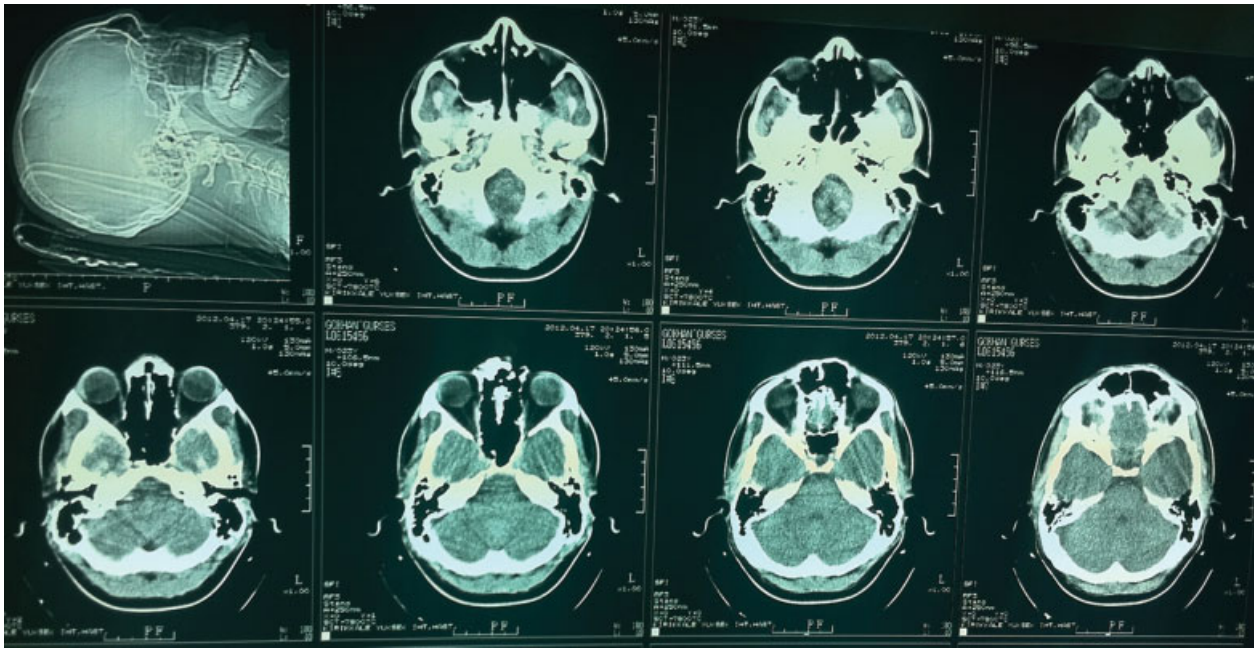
The head computed tomography images of the patient.
